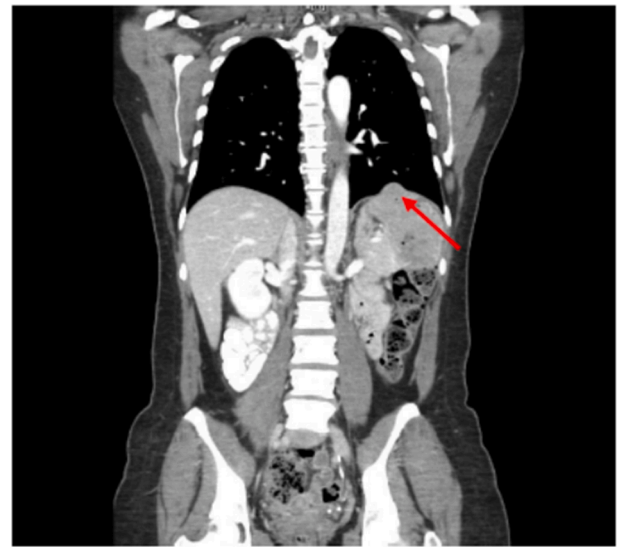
Computed Tomography (CT) scan: small left diaphragmatic hernia (arrow).
